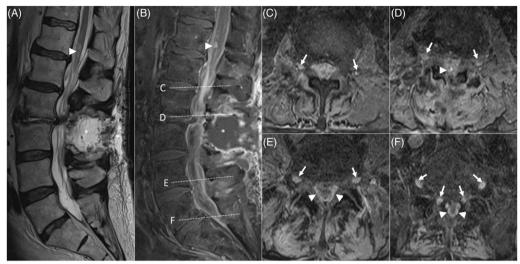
MRI lumbar spine. Sagittal T2-weighted sequence (A) demonstrating severe central canal stenosis from posterior disc bulge and thickening of ligamentum flavum at the L2-3 level (\*). Arrow corresponds to axial view (C) with additional axial views immediately above (B) and below (D).
